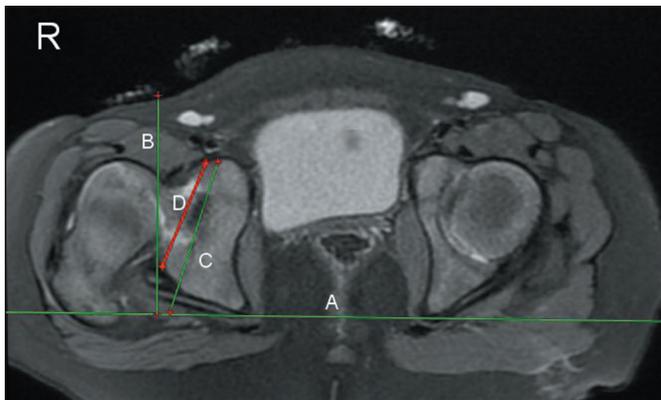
Axial intermediate-weighted fat-suppressed proton density FSE MRI sequence showing the lines employed for the measurement of OAA and CAA. Line A is tangential to the posterior aspect of the ischial tuberosities. Line B is orthogonal to line A. Line C is tangential to the outermost anterior and posterior bony rims of the acetabulum. Line D is tangential to the anterior and posterior chondrolabral junction. OAA is the angle between lines B and C. CAA is the angle between lines B and D. The right hip (R) is dysplastic, and the left hip is normal. Note that the femoral neck on the right side is at the same level as the femoral head on the left side, due to superior displacement of the dislocated femur on the right (dysplastic) side.
